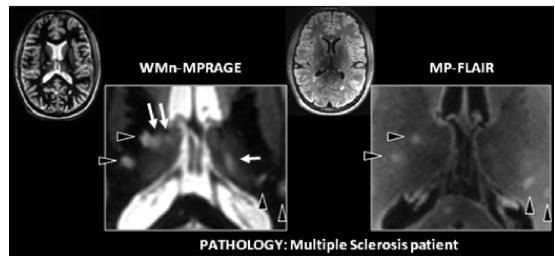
2D-RFB WMn MPRAGE sequence (left) shows thalamic lesions (white arrows) not seen on conventional 3D MP-FLAIR
